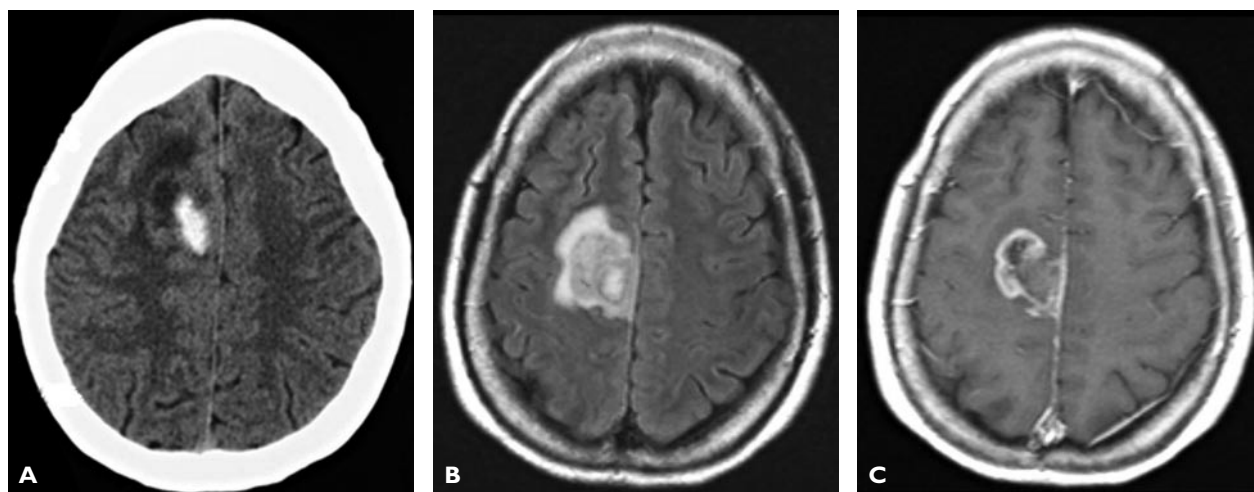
(A) Noncontrast axial computed tomography image of the head reveals an isodense ringed lesion associated with surrounding hypodense edema and hyperdense hemorrhage. (B) T2/FLAIR-weighted magnetic resonance image in the same patient displays a heterogeneous mass with surrounding hyperintense edema. (C) Ring enhancement on a T1-weighted magnetic resonance image with intravenous contrast. FLAIR = fluid attenuation inversion recovery.
